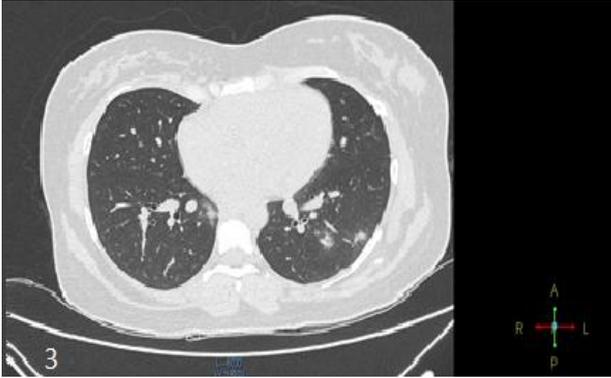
HRCT image of peripheral ground glass opacities (CT scoring 50-75%).
